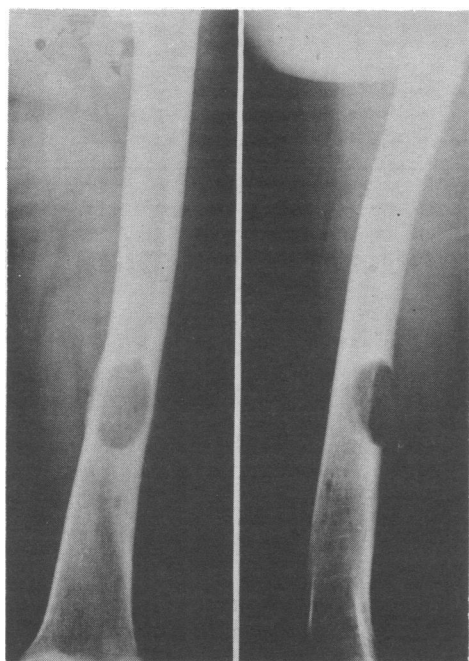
Anteroposterior (left) and lateral (right) radiographs showing 50-75% cortical involvement.
